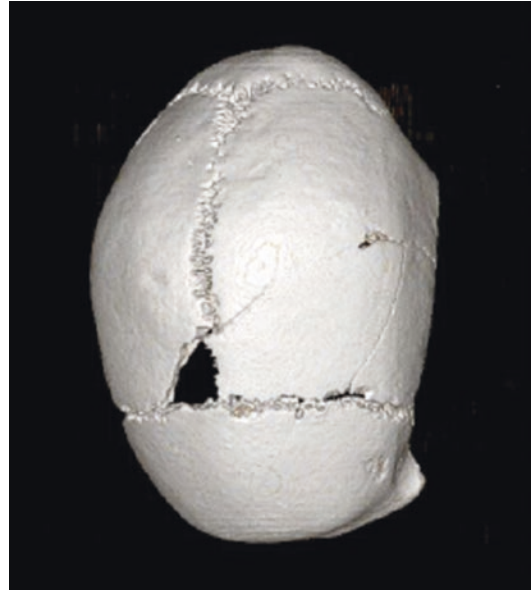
CT of the skull of Valganna (Varese-Northern Italy)
